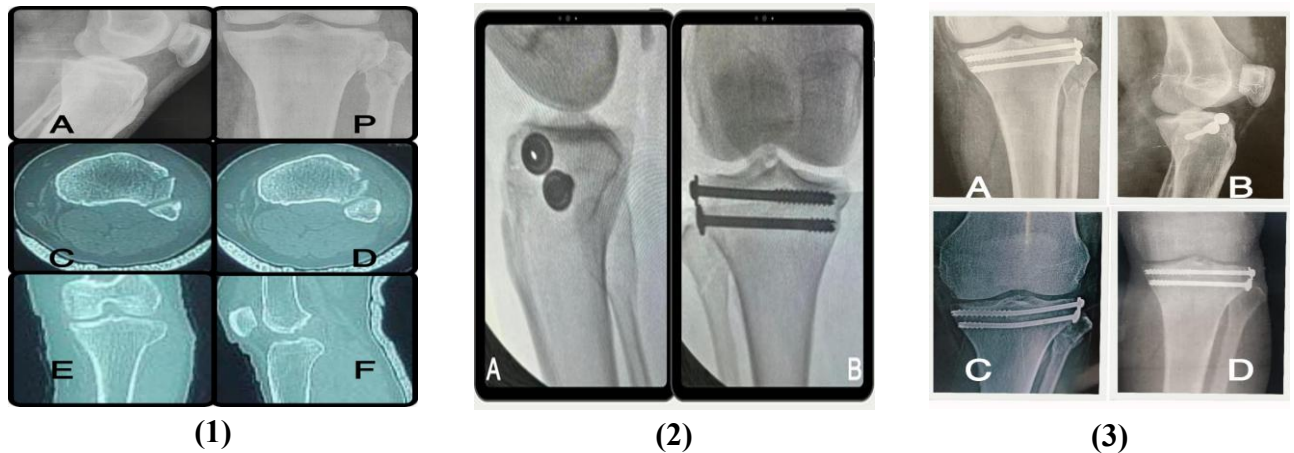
(1) show pre-operative x-ray & Ct type I schatzker tibial plateau fracture, (2) show intraoperative x rays AP and lateral views and (3) show post-operative x ray AP and lateral during 6 months
